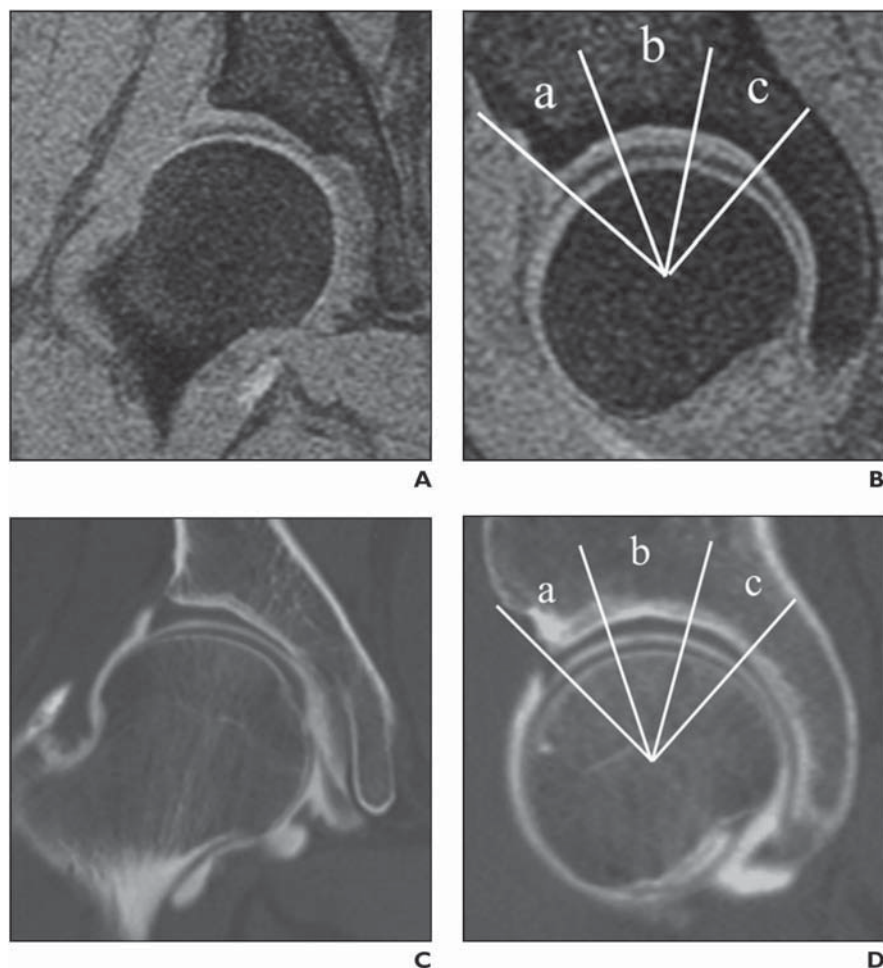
A 40-year-old female patient with right hip dysplasia. (A–D) Midcoronal (A) and midsagittal (B) views of 3-D MR images and midcoronal (C) and mid-sagittal (D) views of CT arthrography images show hip joint. Acetabular and femoral cartilages were evaluated using zone classification shown in midsagittal images (B and D). Weight-bearing area was divided into three 30° ranges: superoanterior (a), superior (b) and superoposterior (c) zones. Source: Nishi *et al.* (2005).
